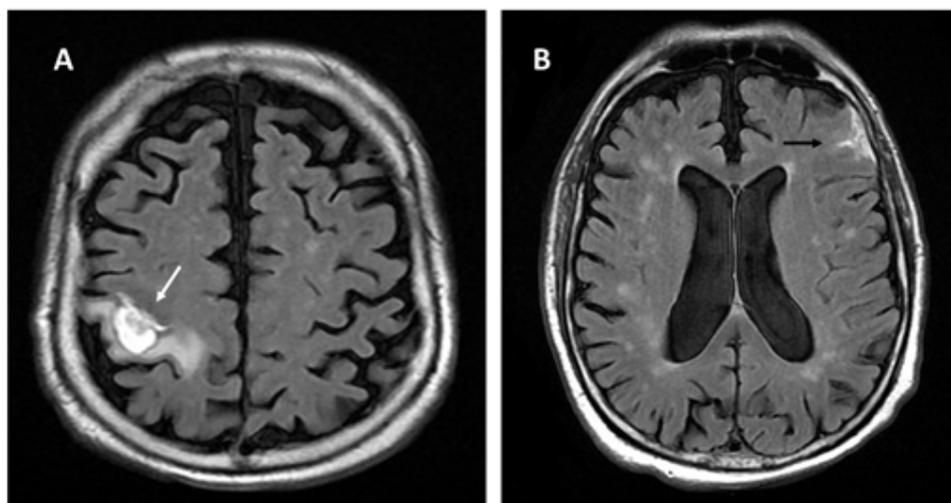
Magnetic resonance imaging of the brain in the T2Flair sequence. Lobar hematoma (white arrow) in the right post-central gyrus (A) and subarachnoid hemorrhage (black arrow) to the left (B).
